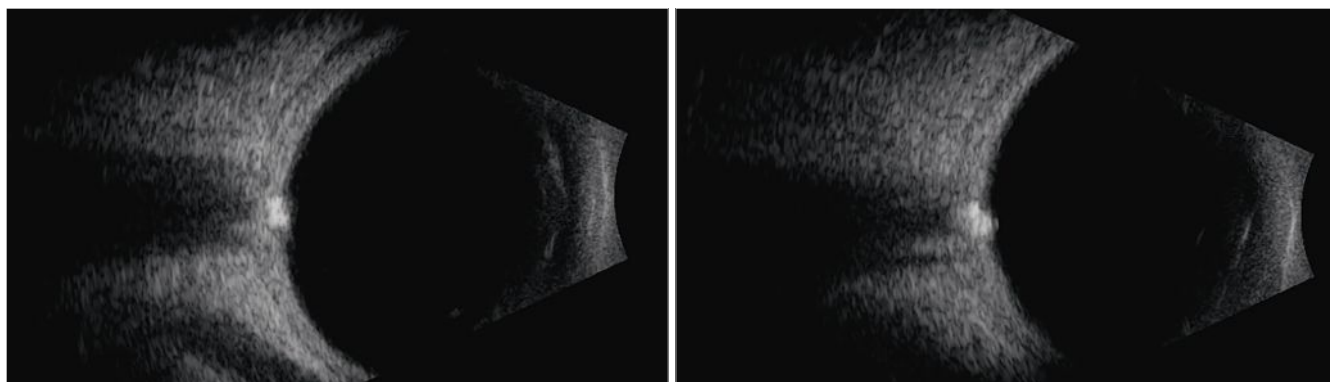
B-scan ultrasound horizontal axial scans over the nerve OD (left) and OS (right).
